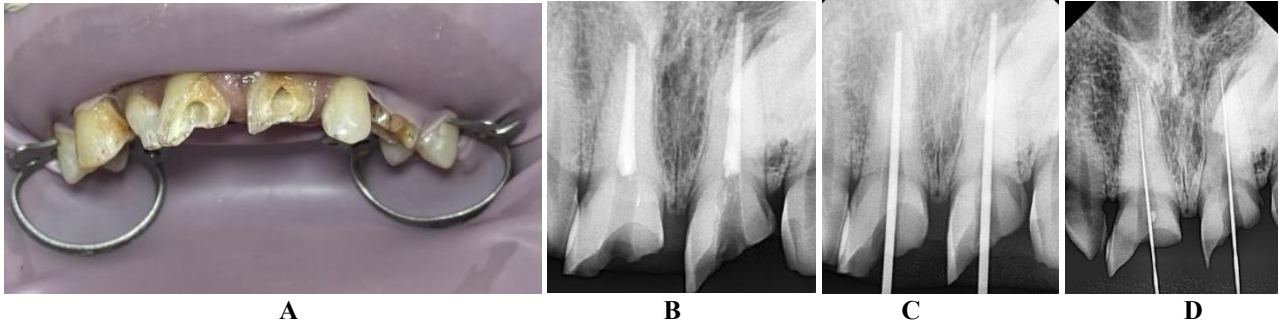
(A) Pulp extirpation was performed in teeth 11 and 21 using barbed broaches. Radiographic (B) Working length determination (C) Master apical cone verification (D) Post-obturation evaluation of teeth 11 and 21
